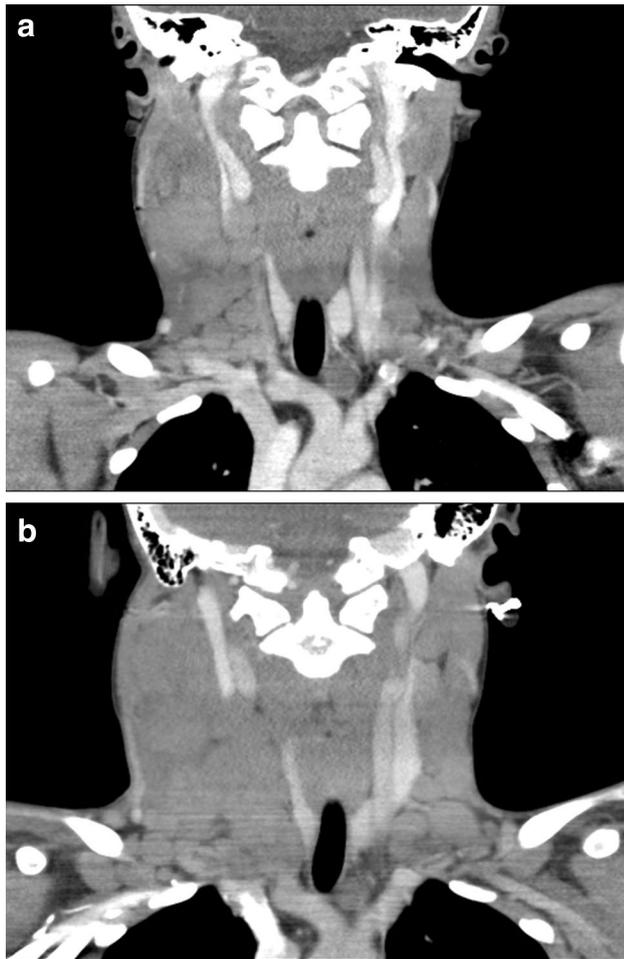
Coronal post-contrast CT image at initial presentation a shows numerous multilevel enlarged and hyperenhancing cervical lymph nodes, right more extensive than left, with surrounding fat stranding. Coronal post-contrast CT image at 3 months follow up b shows generalized increase in size of the lymphadenopathy
